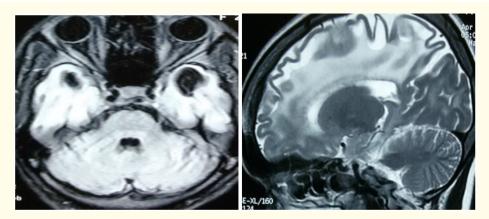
MRI Brain T2 FLAIR and T2 saaggital sections showing cysts in bilateral temporal and frontal region with white matter changes.
